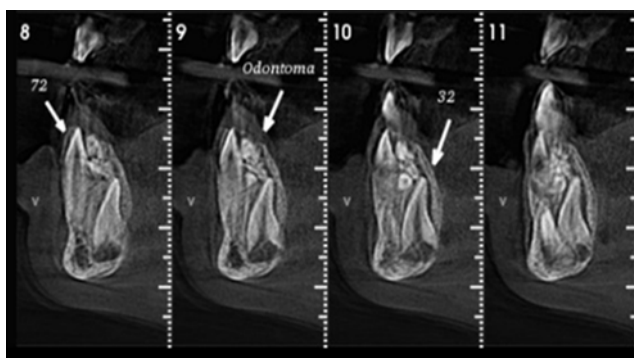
Sagittal cone-beam CT slice showing a compound odontoma lingual to tooth #72 and vestibular to the crown of #32. Both teeth are unerupted
